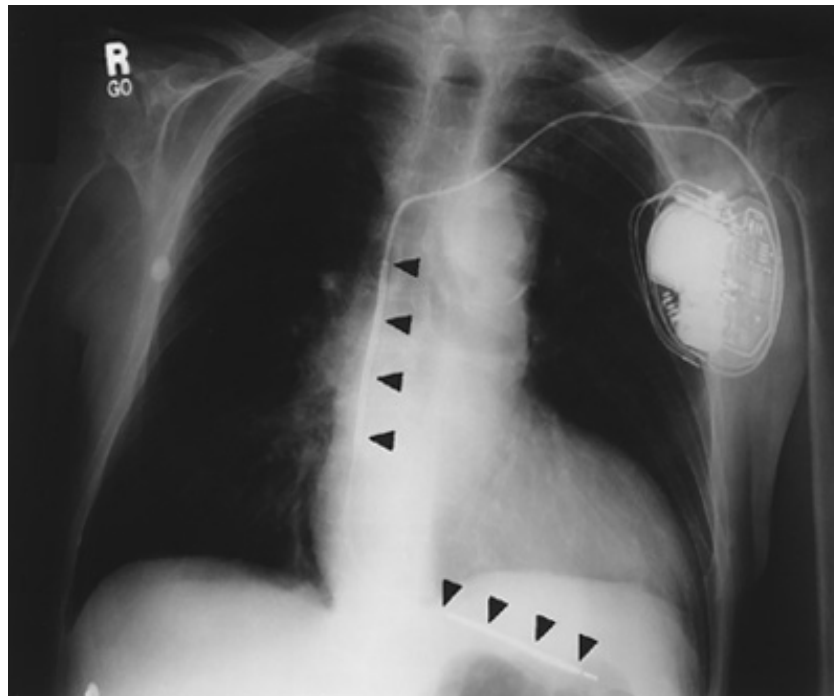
Posteroanterior chest x-ray of pectoral ICD device. A single integrated lead is inserted via the cephalic vein and positioned at the right ventricular apex. This is attached to a pulse generator implanted in the left pectoral region. ICDs are implanted using techniques similar to permanent pacemaker implantation. The integrated lead consists of right ventricular and superior vena cava defibrillation coils (*arrows*) and a tip electrode. In addition to the defibrillation coils, the titanium case of the pulse generator acts as a large-surface-area defibrillation electrode (active can). The defibrillation pathway in this patient is right ventricular coil to both superior vena cava coil and active can.
